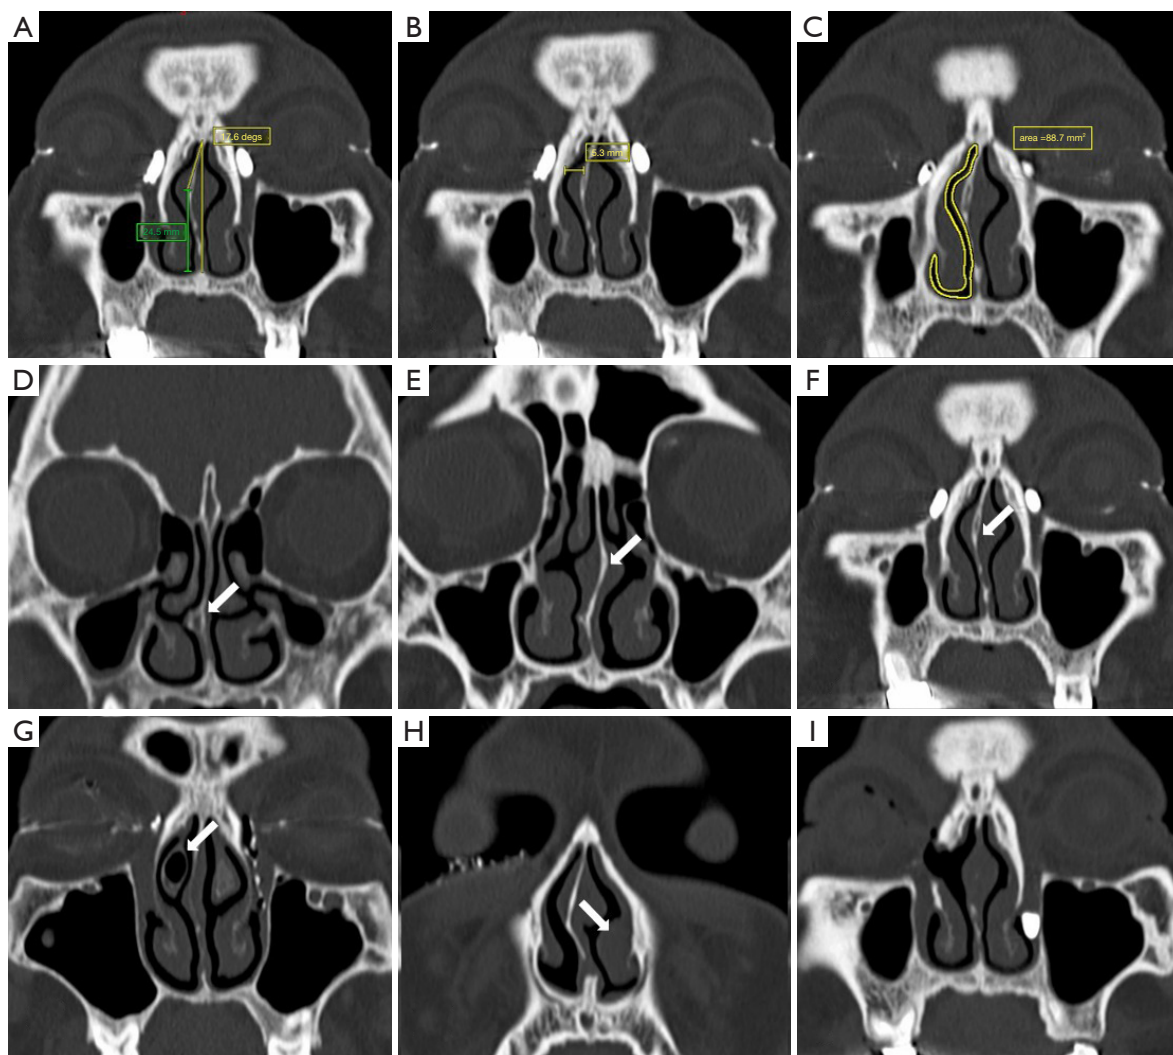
Anatomic characteristics measured and evaluated by computed tomography. (A) The angle of NSD was measured on coronal CT images as the angle between the most deviated point of the septum and the midline. The height of NSD was the vertical distance from the apex of NSD to the floor of the nasal cavity and was measured parallel to the midline (green line). (B) The MNPW on the surgical side was measured in the coronal plane by selecting the level with the largest lacrimal sac visualization and was defined as the distance between the frontal processes of maxilla and the nasal septum on the operated side. (C) The minimal cross-sectional intranasal areas of the surgical passage were identified at the surgical region and then outlined and calculated. (D-H) The modified Guyuron classification of septal deformities: (D) septal tilt and localized spicule, (E) S-shaped anteroposterior and cephalocaudal septal deviations, (F) C-shaped anteroposterior and cephalocaudal septal deviations, (G) concha bullosa on the surgical side, and (H) inferior turbinate hypertrophy on the nonsurgical side (white arrows). (I,F) Images from the same patient with bilateral PANDO; the right eye was the first to be treated with En-DCR in combination with septoplasty. (I) Image obtained during the preoperative examination of this patient's left eye, which indicated a patent anastomosis and a well-corrected septum in the right eye after surgery. NSD, basal septal deviation; CT, computed tomography; MNPW, middle nasal passage width; PANDO, primary acquired nasolacrimal duct obstruction; En-DCR, endonasal endoscopic dacryocystorhinostomy.
